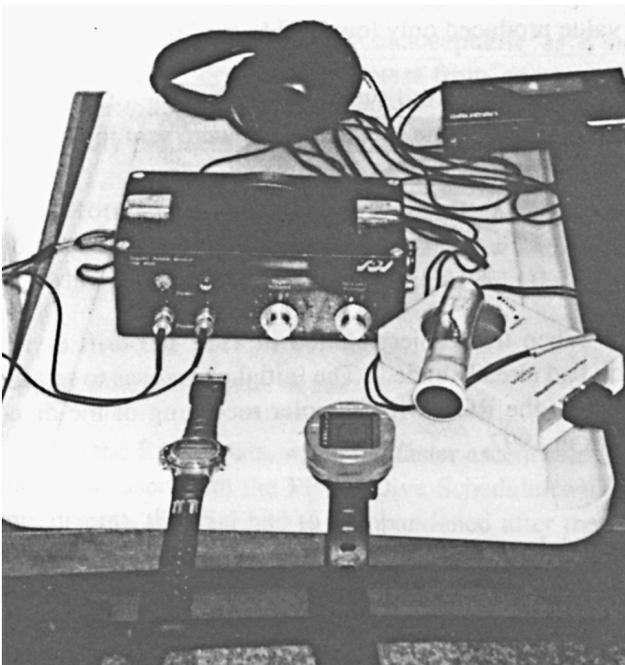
Equipment for Doppler monitoring. Showing chest probe, Suunto depth recorder, Hyperaqualand depth/time recording watch, tape recorder and ear phones.
